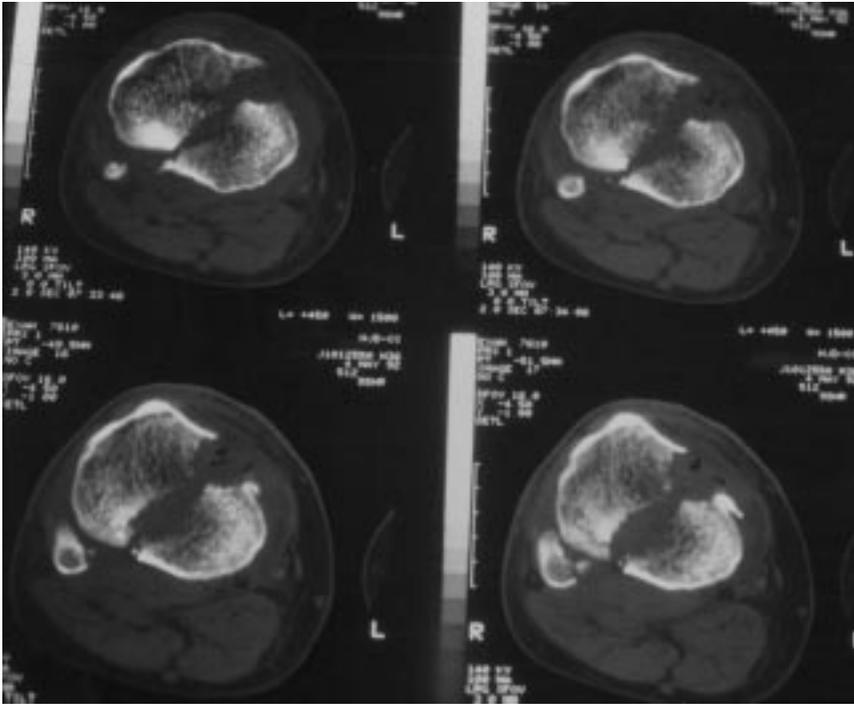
Computed tomographic scans of a displaced tibial plateau fracture. Such a study is useful in planning lag-screw location and direction, particularly with use of indirect reduction.
